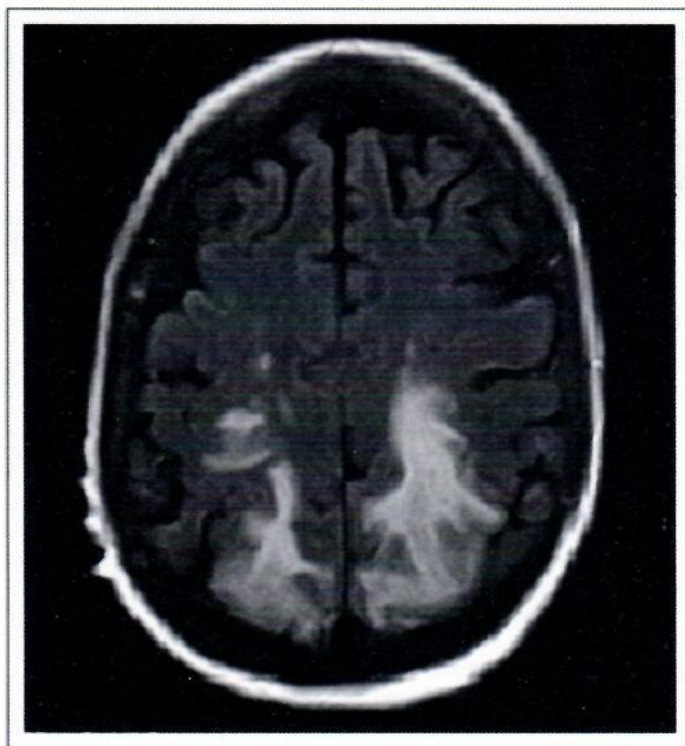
Cranial CT showing Posterior Leukoencephalopathy; jco.ascopubs.org, accessed October 12, 2014; 10:55am.
